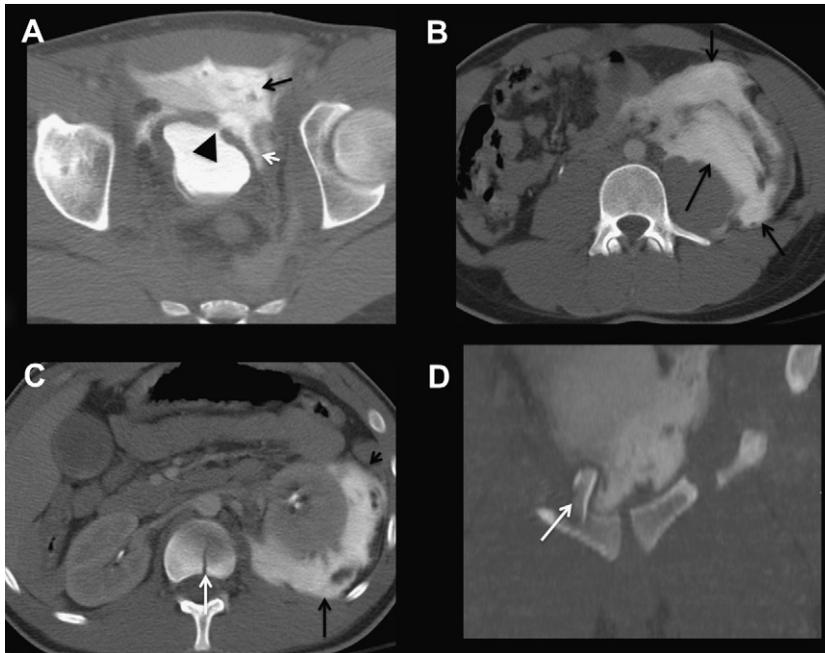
Complex extraperitoneal bladder rupture. (A) Axial CT scan through the base of the bladder demonstrates extravasation of contrast into the prevesicular (*black arrow*) and perivesical spaces (*white arrow*). The location of bladder perforation is indicated (*black arrowhead*). (B and C) Axial CT scans at progressively more superior levels demonstrate contrast material dissecting through fascial planes in the left retroperitoneum and extending into the perirenal and posterior pararenal spaces (*black arrows*). Note the sagittal lumbar spine fracture (*white arrow* in image C). (D) Coronal CT scan of the pelvis demonstrates a displaced fracture fragment of the right pubic rami (*white arrow*) as a possible source for bladder perforation seen in A.
